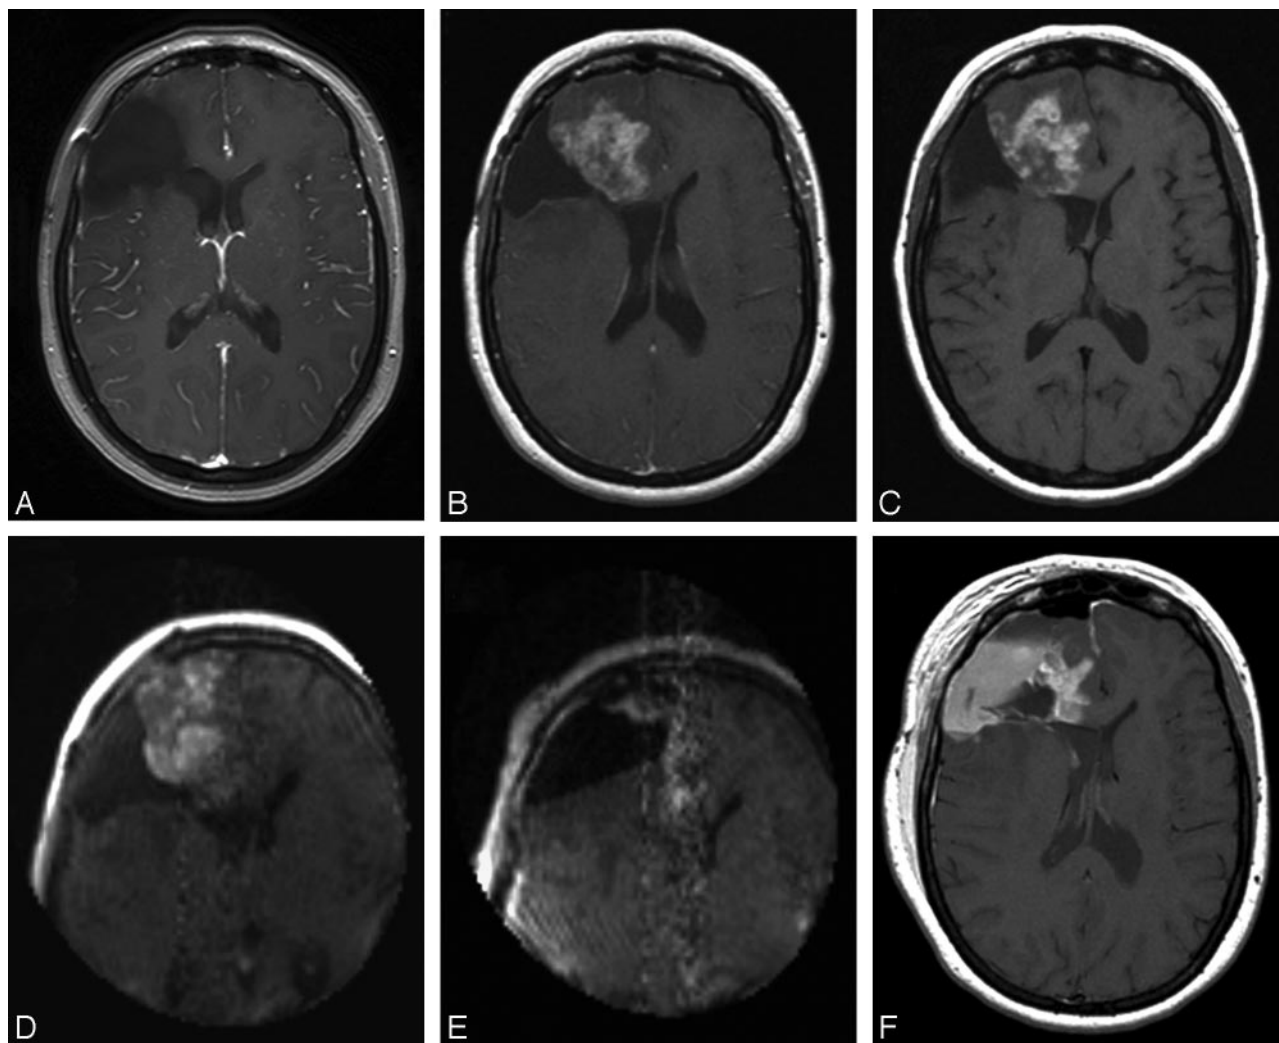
T1-weighted MR imaging in a patient with recurrence of a low-grade astrocytoma. The patient had stable disease after previous craniotomy (A) but showed recurrence on gadolinium images in March 2005 (B). The patient received ferumoxtran-10, and 24 hours later underwent preoperative MR imaging (C) as well as MR imaging with the 0.15T intraoperative scanner before (D) and during (E) craniotomy. Postoperative MR imaging (F) correlated with the residual areas of enhancing tumor seen on intraoperative MR imaging. High signal intensity in the tumor cavity, not present on intraoperative MR imaging, demonstrates the problem of differentiating residual enhancing tumor from blood products. Because the ferumoxtran-10 persists for 4–7 days, the postoperative MR images were exactly the same with or without the addition of gadolinium.
